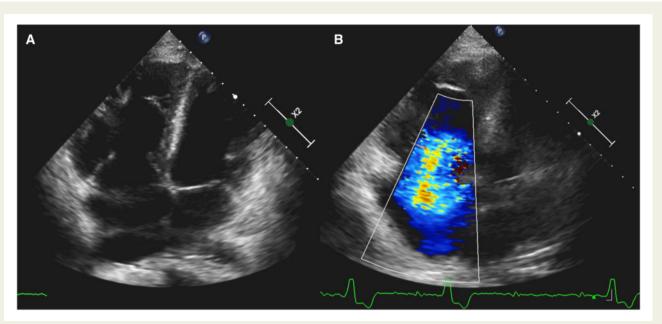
Figure I (A) Transthoracic echocardiogram demonstrating severe right ventricular dilatation. (B) Colour Doppler demonstrating severe tricuspid regurgitation.
